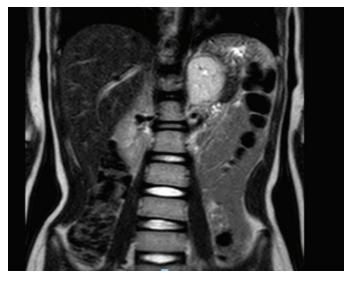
Magnetic resonance image shows a huge mass in the left adrenal gland.
